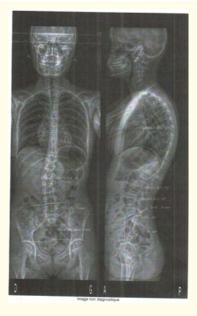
Xray of the patient in the two plans.
